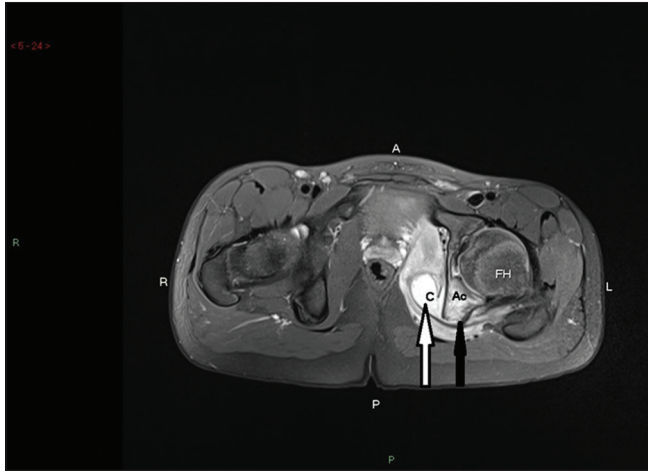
Axial T-2 weighted magnetic resonance imaging at the level of hip joint showing left intra-pelvic collection (white arrow) and increased signal in the ischium (black arrow) (FH: Femoral head, Ac: Acetabulum, C: Collection, A: Anterior, P: Posterior, L: Left, R: Right)
